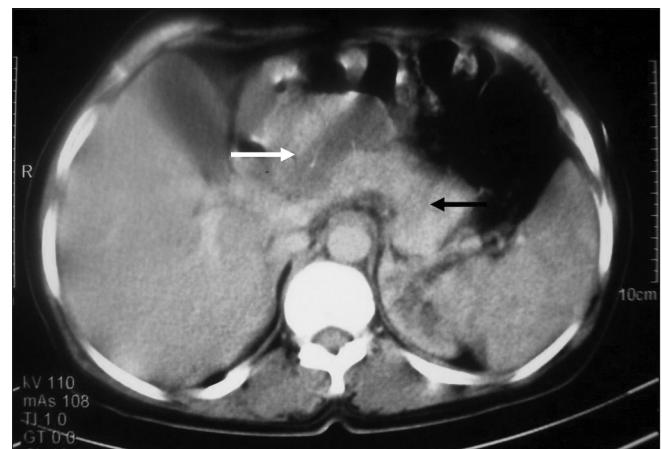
CT scan revealing growth in the stomach wall (white arrow) infiltrating into the pancreas (black arrow)
